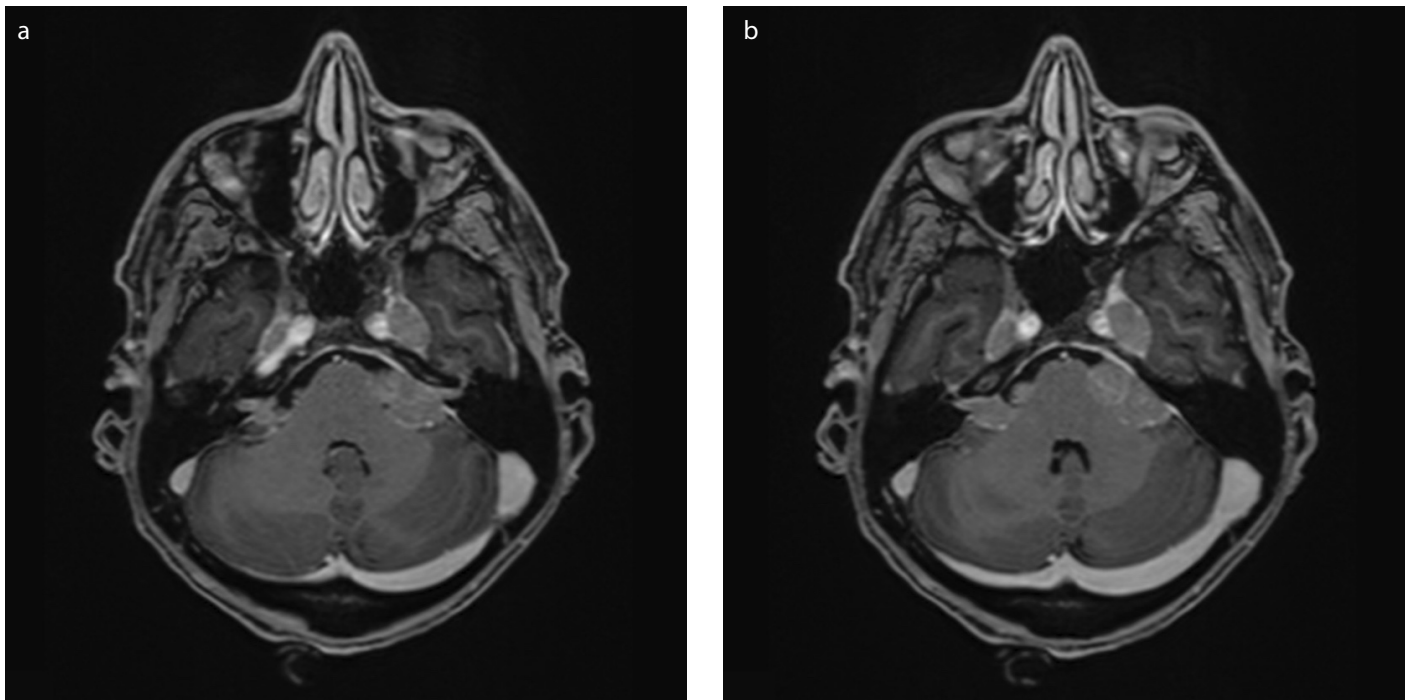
a, b. T1-weighted magnetic resonance imaging scan of the brain at the level of the IAC after intravenous administration of gadolinium. The scan shows bilateral masses in the IAC and CPA, which show contrast enhancement.
